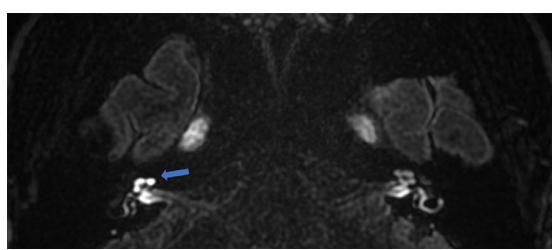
Magnetic resonance imaging (MRI) example scan of a 69-year-old male with a clinical diagnosis of definite Ménière's disease in the right ear. The axial plane, delayed Gd-enhanced images did not show endolymphatic hydrops according to Barath and Bernaerts scales. However, perilymphatic enhancement is increased in the cochlea (pointed by an arrow) on the affected side compared to the contralateral normal inner ear, indicating impairment of the blood-perilymph barrier.
